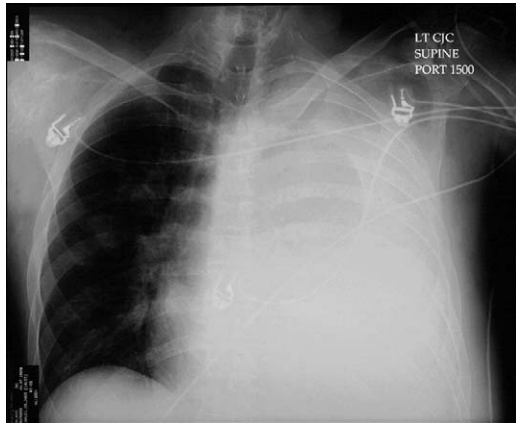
Initial chest radiograph shows a large left pleural effusion and rightward tracheal deviation.
